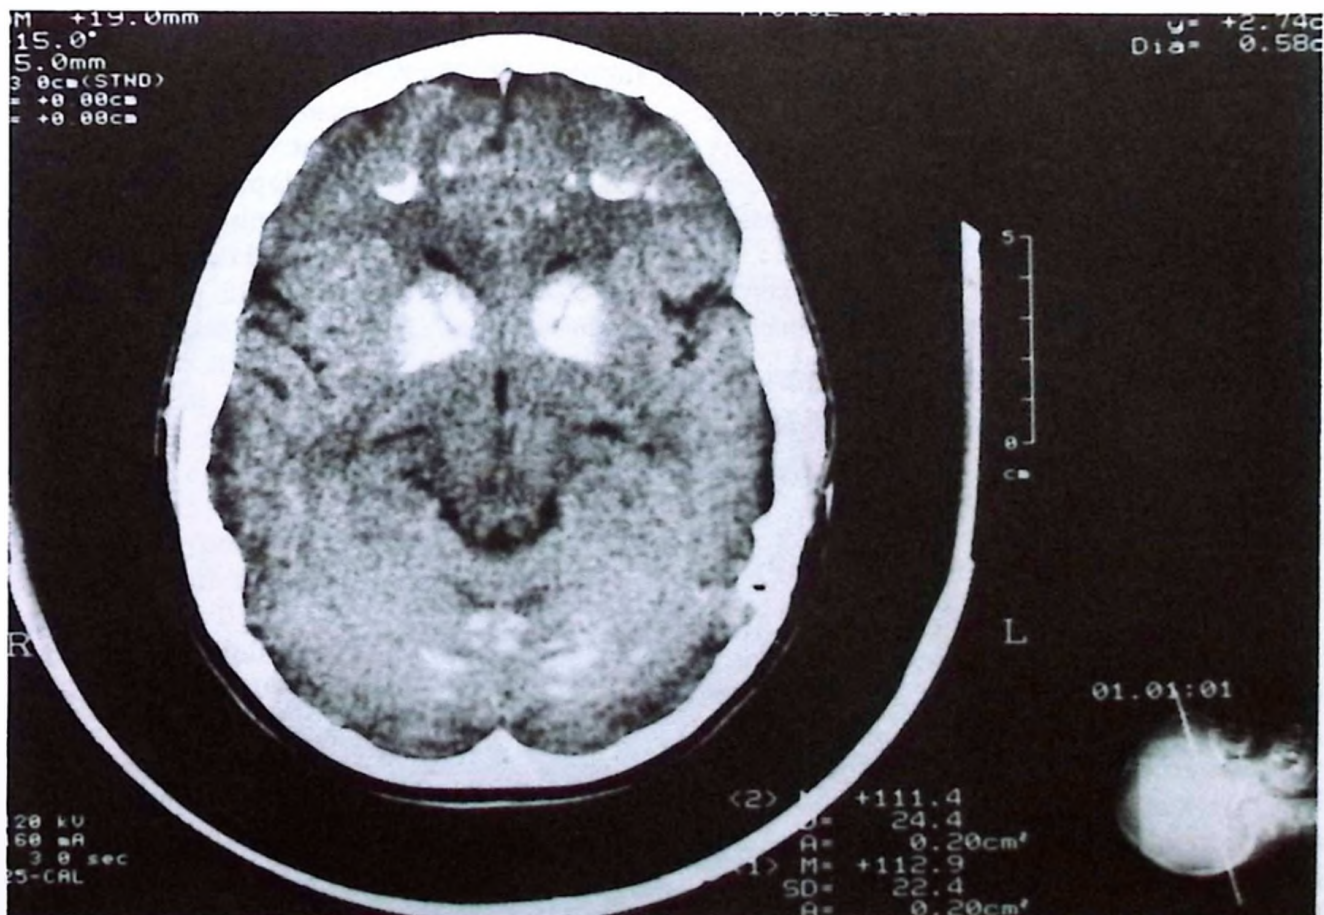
Calcifications in basal ganglia as revealed by CT.
